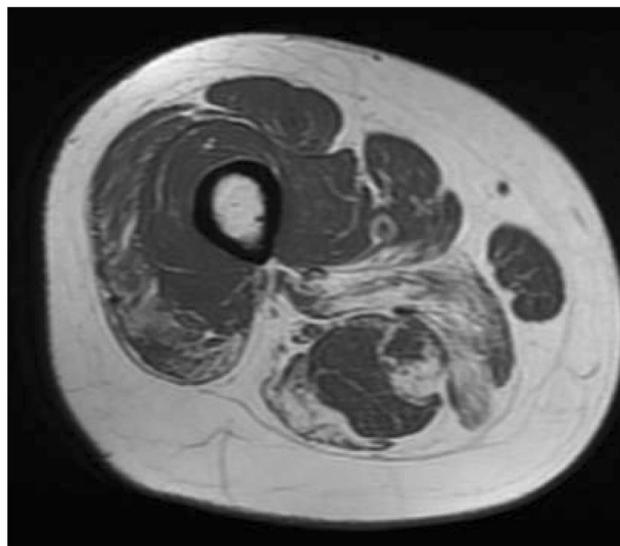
Example of T1-weighted fast spin-echo sequence showing fat replacement (white areas inside the muscle) notably in the posterior and medial compartments. This is our patient with the greatest degree of fat replacement
